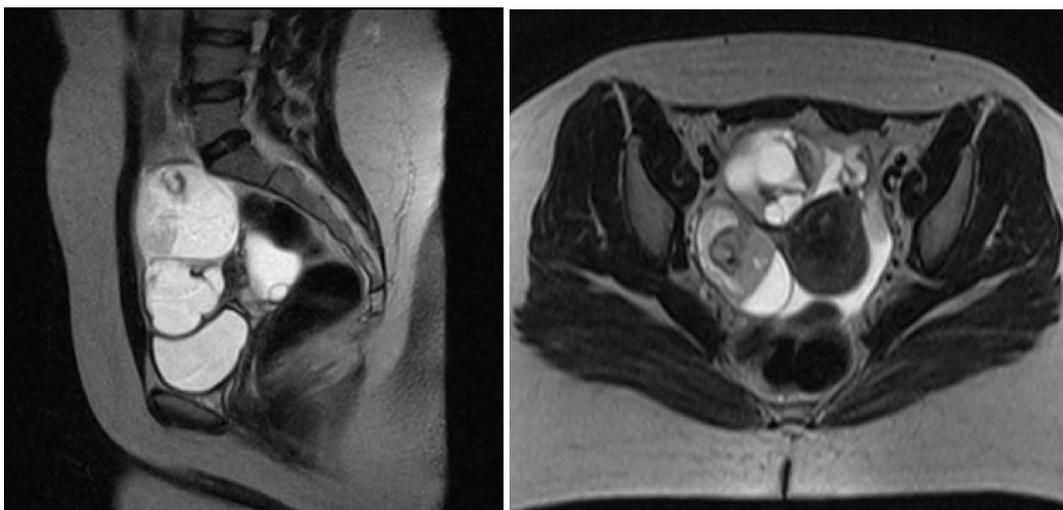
MRI of the pelvis showing right adnexal mixed solid and cystic mass with heterogeneous signal intensity; Papillary serous carcinoma (Top: Sagittal view; Bottom: Axial view)
